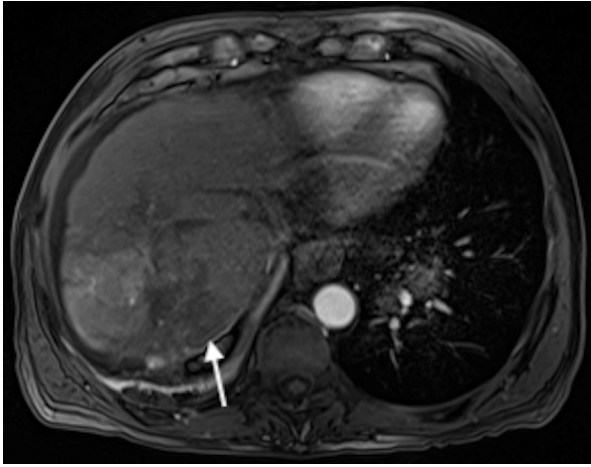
Magnetic resonance imaging after balloon-assisted transarterial chemoembolization of hepatic arterial branches supplying the segment 7 mass demonstrates minimal residual enhancement in the treatment cavity (white arrow).
